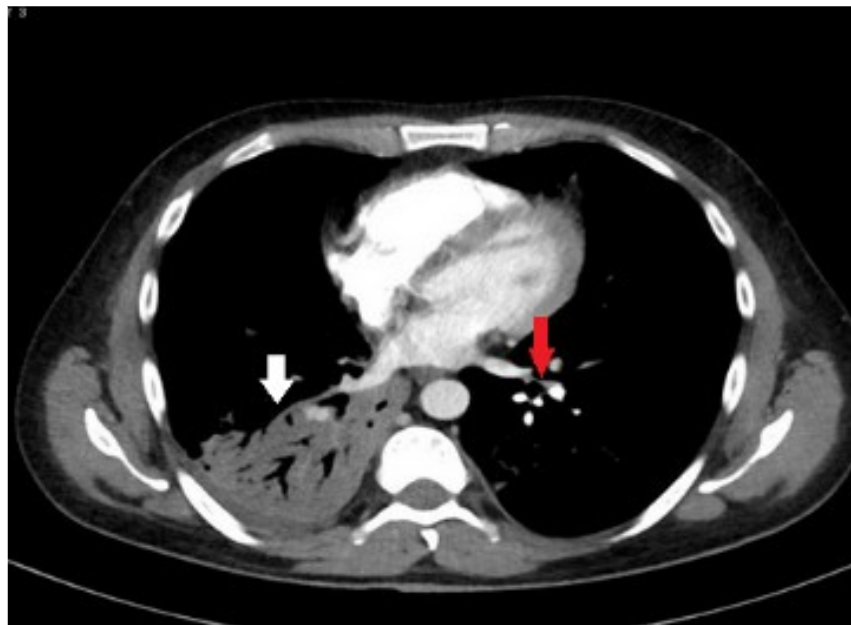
CT pulmonary angiogram (CTPA) remarkable for consolidation marked with white arrow on the right side and area of filling defect in the left pulmonary artery marked with red arrow
